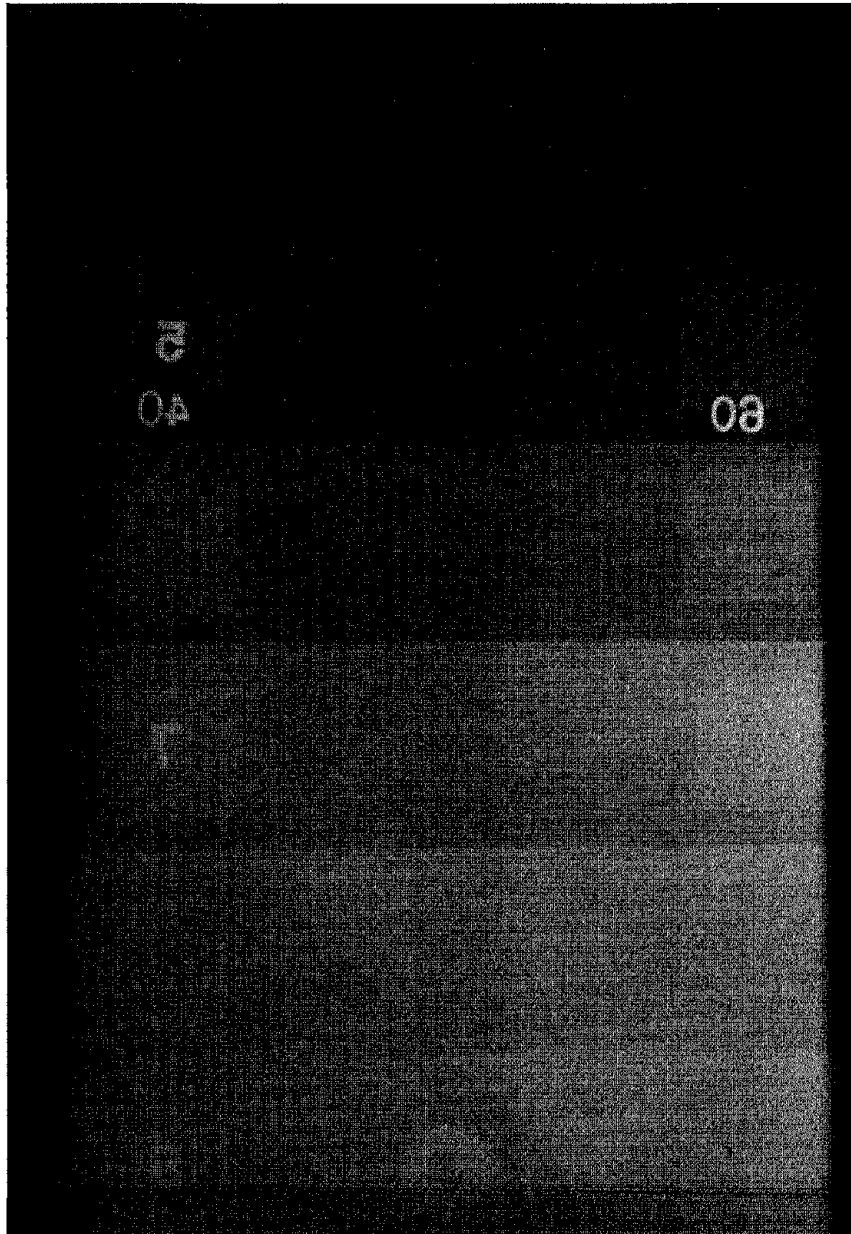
Radiograph chest test object where centering is poor.
